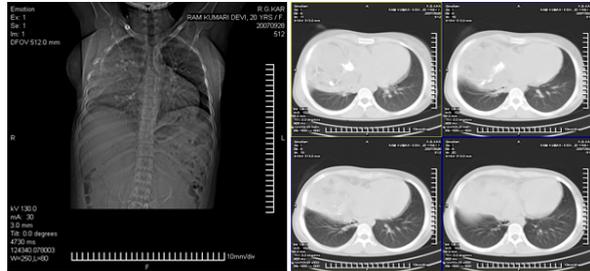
CT Scan showing Anterior Mediastinal heterogeneous mass
